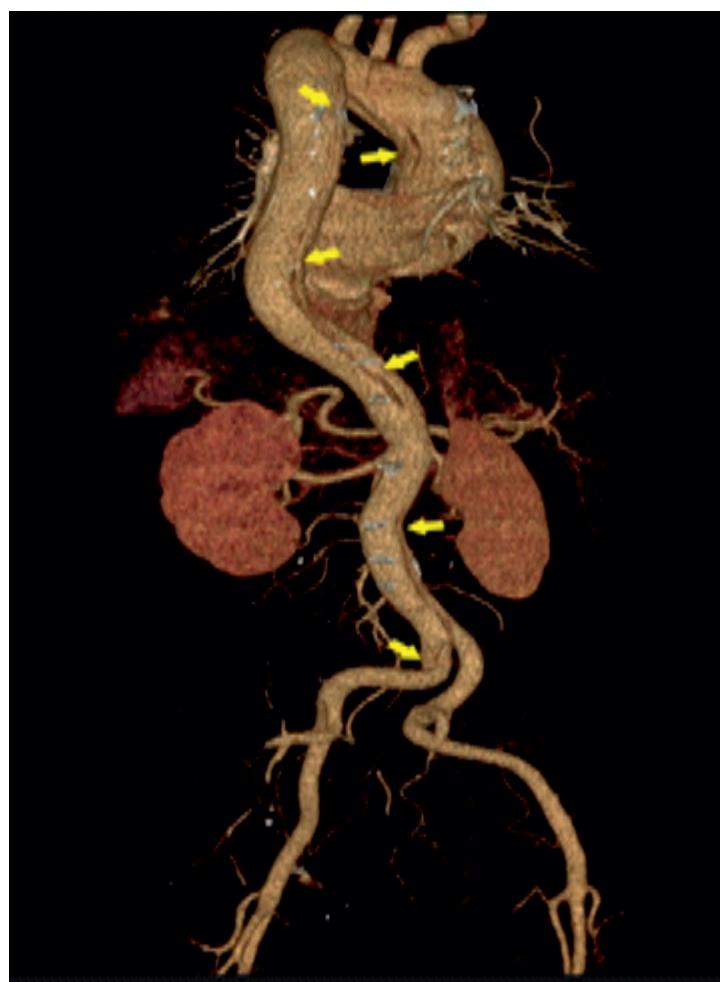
3D reconstruction of CT angiography reveals a dissecting aneurysm, involving both the ascending and descending aorta throughout its entire length, extending to the left common iliac artery (type A and B according to the Stanford classification).
